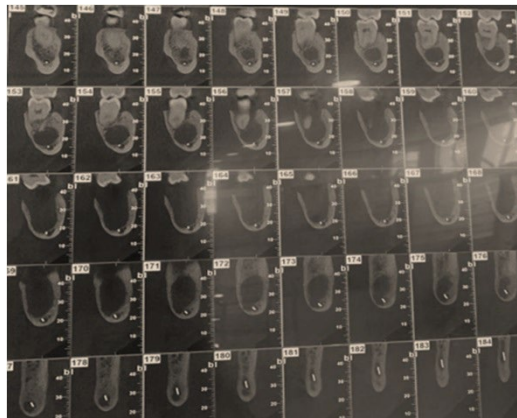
CBCT after 12 months of marsupialization.
